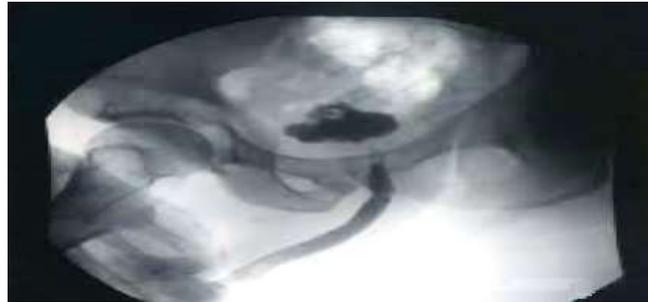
Case No. 12.. CT scan showing urethral rupture in a patient with penile contusion involving the corpus spongiosum.
